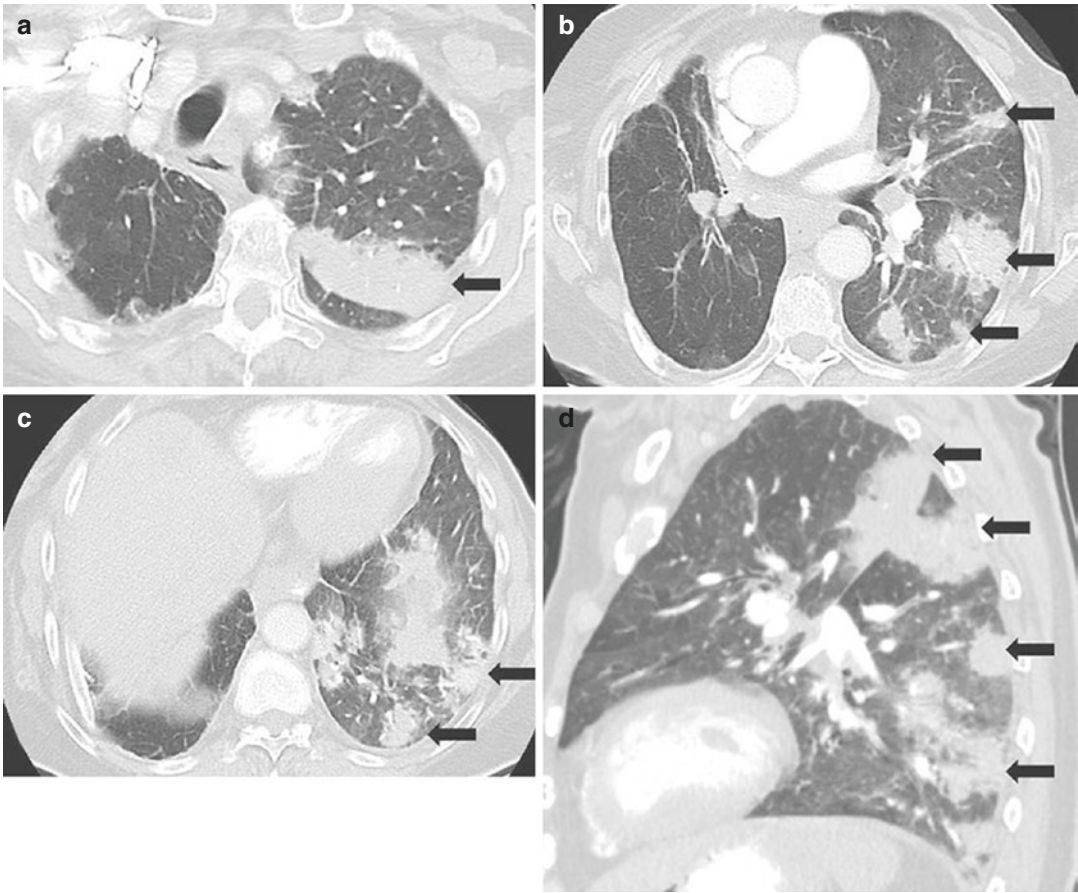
An 83-year-old woman with recurrent NSCLC treated with nivolumab, presenting with an increasing dry cough, dyspnea, and hypoxemia after 4 weeks of therapy. (Reprinted from *Cancer Immunol Res.* 2016 Apr;4(4):289–93). (a–d) Axial (a–c) and sagittal (d) images of chest CT
